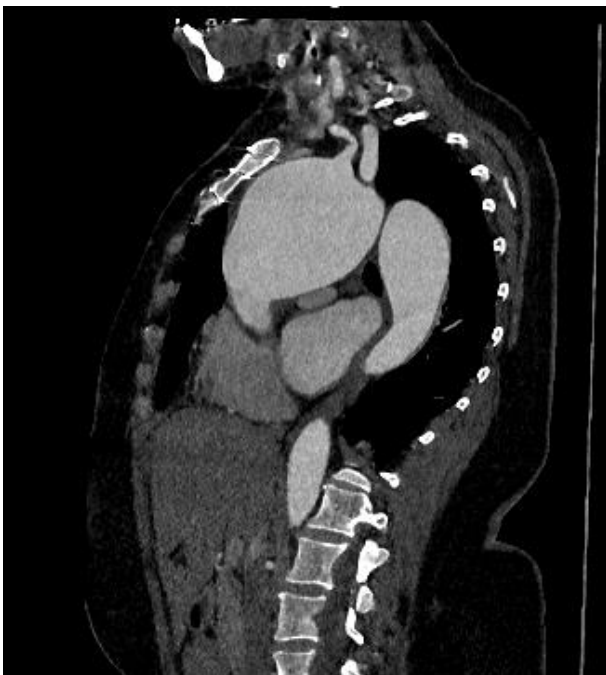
Three-dimensional computed tomographic aortic reconstruction. Shows the giant ascending aortic, arch, and descending aortic aneurysm
